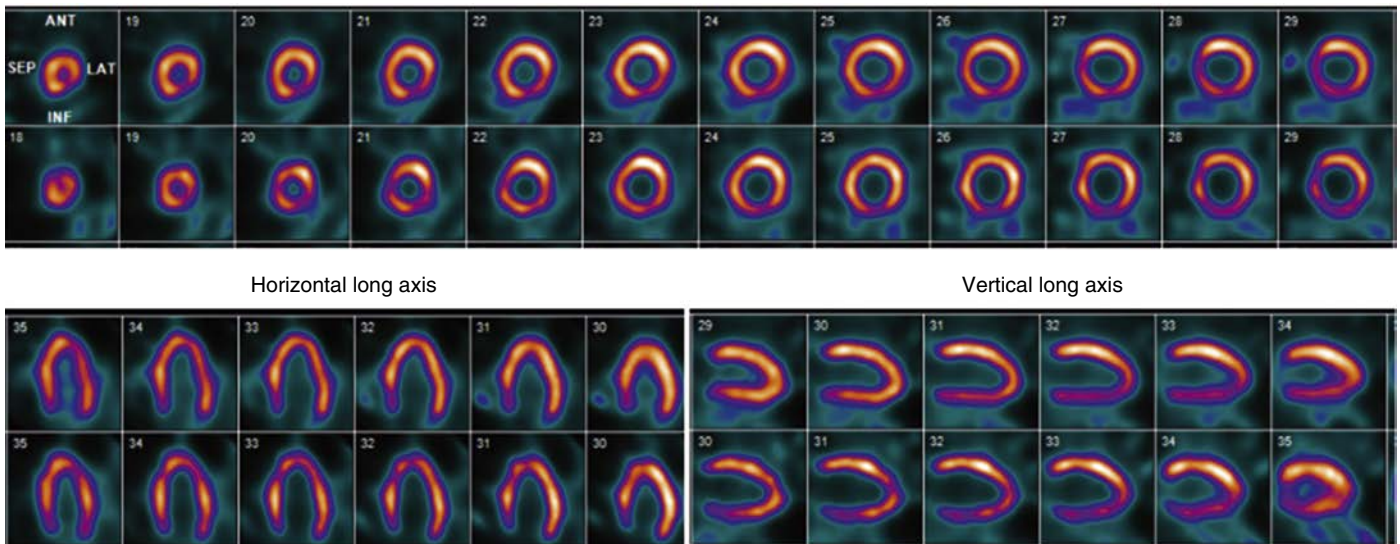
Images for Case Vignette 1. Stress and rest technetium-99m (^{99m}Tc) myocardial perfusion single positron emission computed tomography (SPECT) images. See text for details.
